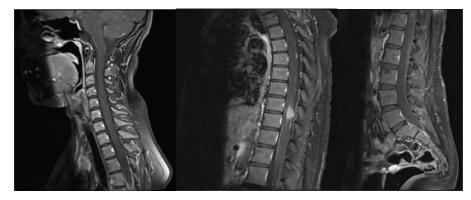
MRI spine T1 with contrast sagittal cervical, thoracic and lumbar spine
